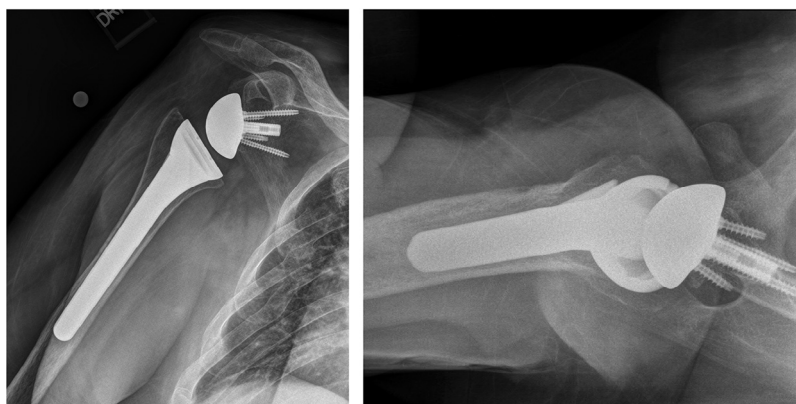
Postoperative anteroposterior and axillary radiographic views of same patient in Figure 1 showing reverse arthroplasty in good position.
